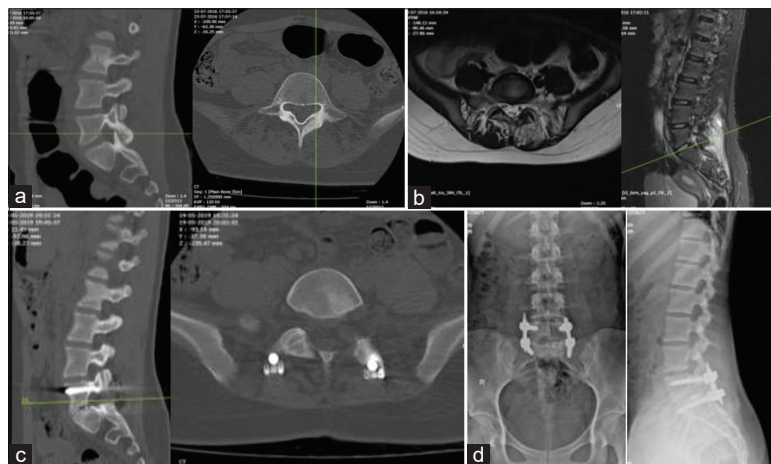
(a) Sagittal and axial CT scan demonstrating osteoid osteoma involving left L5 pedicle and lamina. (b) Sagittal and axial T2-weighted MRI showing lesion involving left L5 pedicle and lamina. (c) Postoperative CT scan demonstrating complete excision of lesion. (d) Postoperative AP and lateral X-ray showing pedicle screw fixation (L5, S1).
